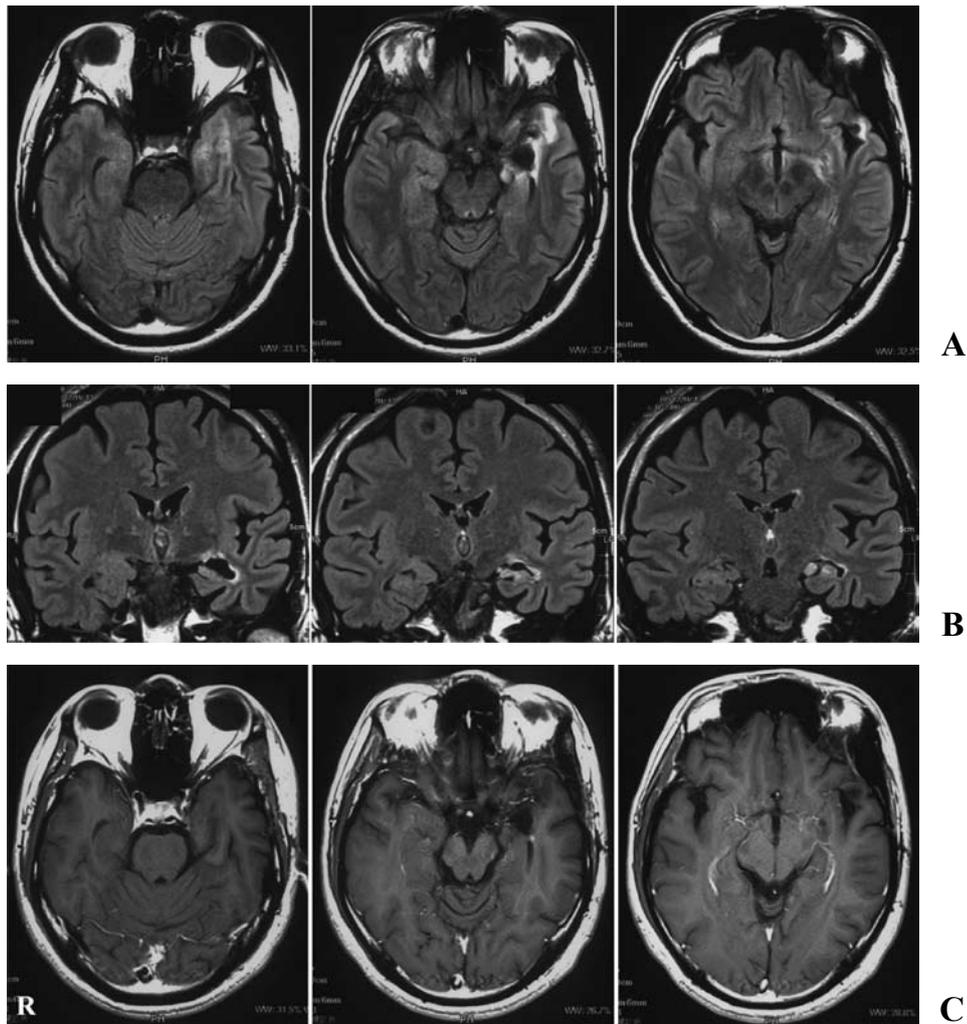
Magnetic resonance imaging (MRI) performed prior to operation attempt 2. Axial (A) and coronal (B) fluid-attenuated inversion recovery (FLAIR) images showed hyperintense hippocampal atrophy on the left side adjacent to a cavity of the initially operated site. A gadolinium (Gd)-treated axial T1-weighted image (C) did not portray any enhanced lesion.
